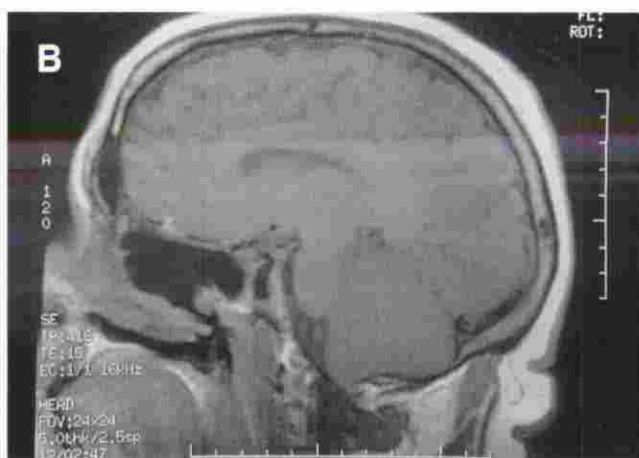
MRI showing a well-healed skull base in the (A) coronal and (B) sagittal plane with no evidence of tumor recurrence at 2.5 years postoperatively.
